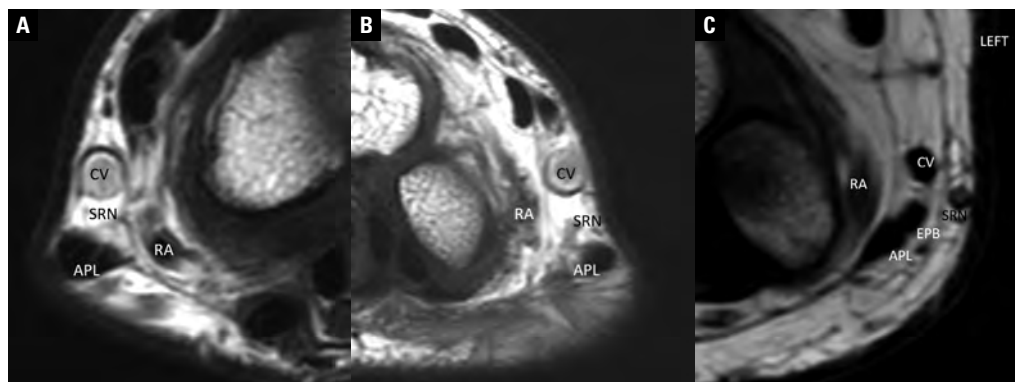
Magnetic resonance imaging sections at the level of radiocarpal articulation of the right limb (A) and the left limb (B) show bilaterally a sole tendon of abductor pollicis longus (APL) in the first extensor compartments. A corresponding section through a normal left wrist of another patient is shown for the reference (C); EPB — extensor pollicis brevis; CV — cephalic vein; SRN — superficial branch of the radial nerve; RA — radial artery.
